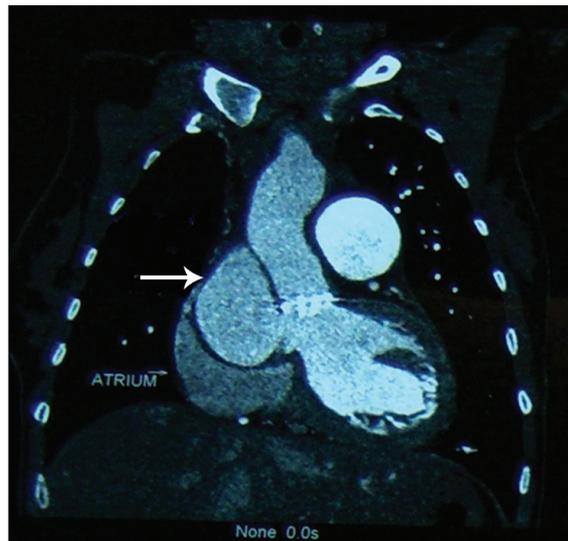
Thoracic computed tomography scan revealed a pseudoaneurysm (arrow), 14.5 cm in diameter, compressing the superior vena cava and right atrium
